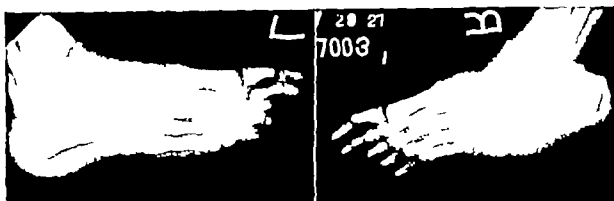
J. P. Roentgenograms of both feet, showing unilateral deformity. The talus of the right foot is underdeveloped and is in a vertical position. The calcaneus is tilted downward, and there is a convexity at the sole. The navicular bone articulates with the neck of the talus.
